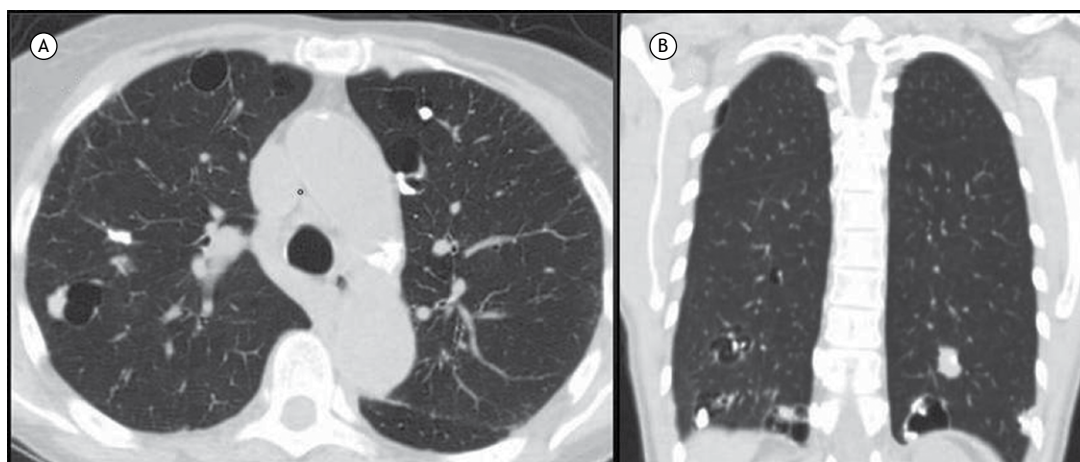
In A, axial reconstruction of a CT scan demonstrating several thin-walled, cystic structures associated with adjacent nodules, some of which were calcified. In B, coronal reconstruction of a CT scan showing randomly distributed lung cysts and associated nodules. The patient in question was a 56-year-old female and was diagnosed with Sjögren's syndrome and amyloidosis-related lung involvement.
